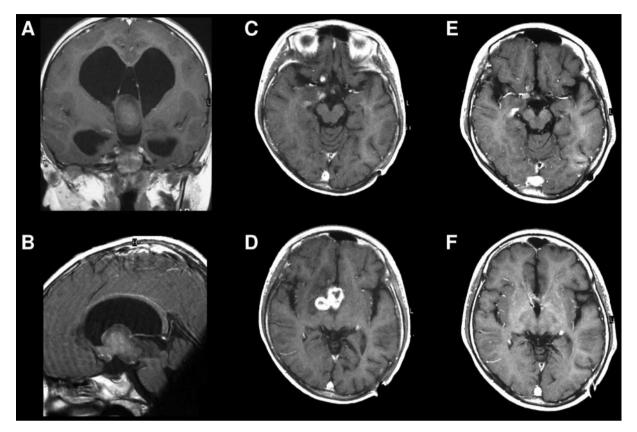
Case 5. Gadolinium-enhanced coronal (A) and sagittal (B) brain MR images show a slightly enhanced solid mass within the third ventricle. It was accompanied by obstructive hydrocephalus. Four years after the second surgery, gadolinium-enhanced brain MR images show a recurrence of the tumor (C and D). Gadolinium-enhanced brain MR images after twelve courses of chemotherapeutic treatment show remarkably reduced tumor enhancements (E and F).
